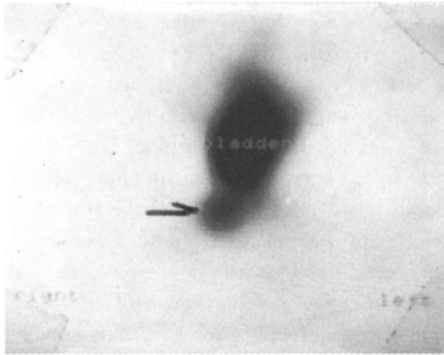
A postoperative patient of rectal carcinomara with an elevated serum CEA level; CT scan found nothing abnormal but a slight thickening of the scar tissue, while RII disclosed a tumor recurrence at the site of scar tissue.
